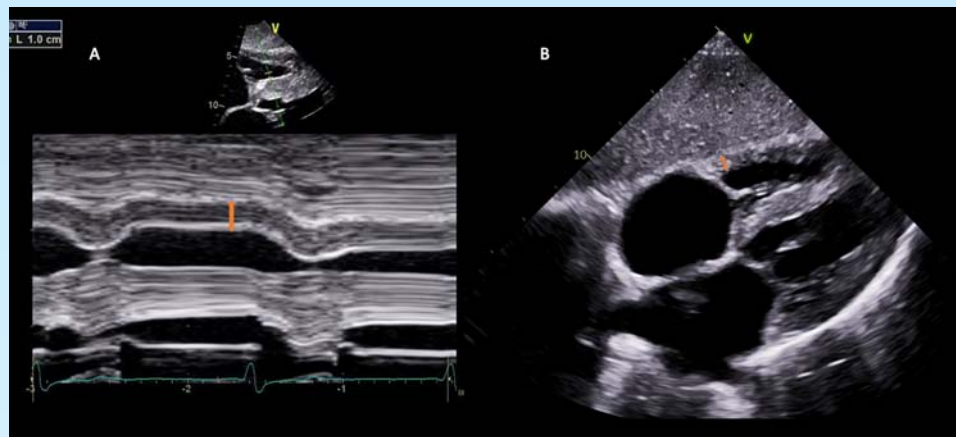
(A) M-mode echocardiography is used in the subcostal 4-chamber view to measure the RV free wall thickness. (B) Two-dimensional RV wall thickness measurement in the subcostal 4-chamber view. Correct measurements are shown with the *orange arrow*.
